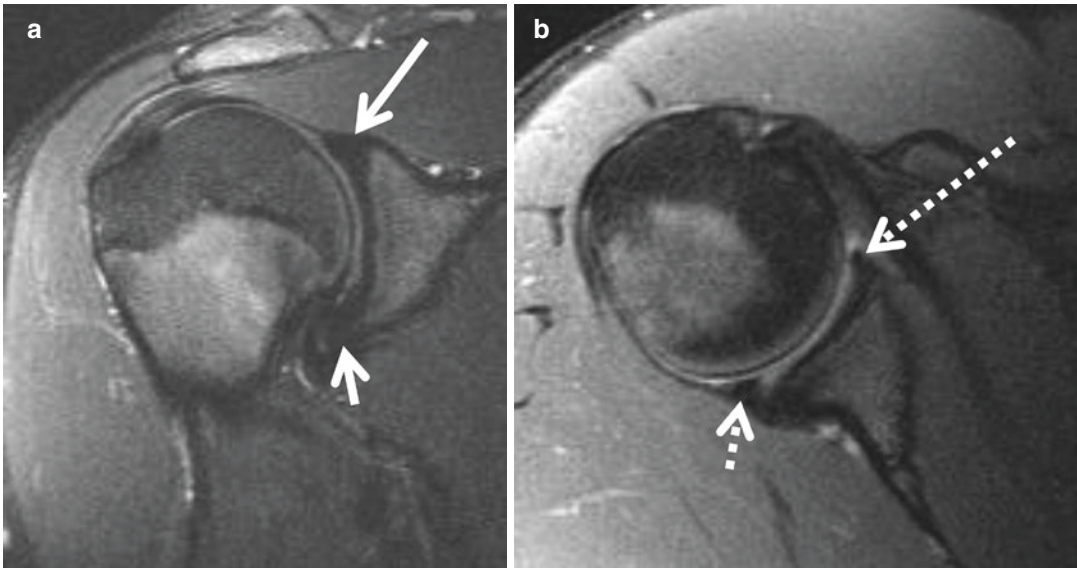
Normal glenoid labrum. (a) Coronal oblique proton density fat-suppressed and (b) axial T2-weighted fat-suppressed (b) images demonstrating a normal hypointense triangular contour to the superior (long solid
